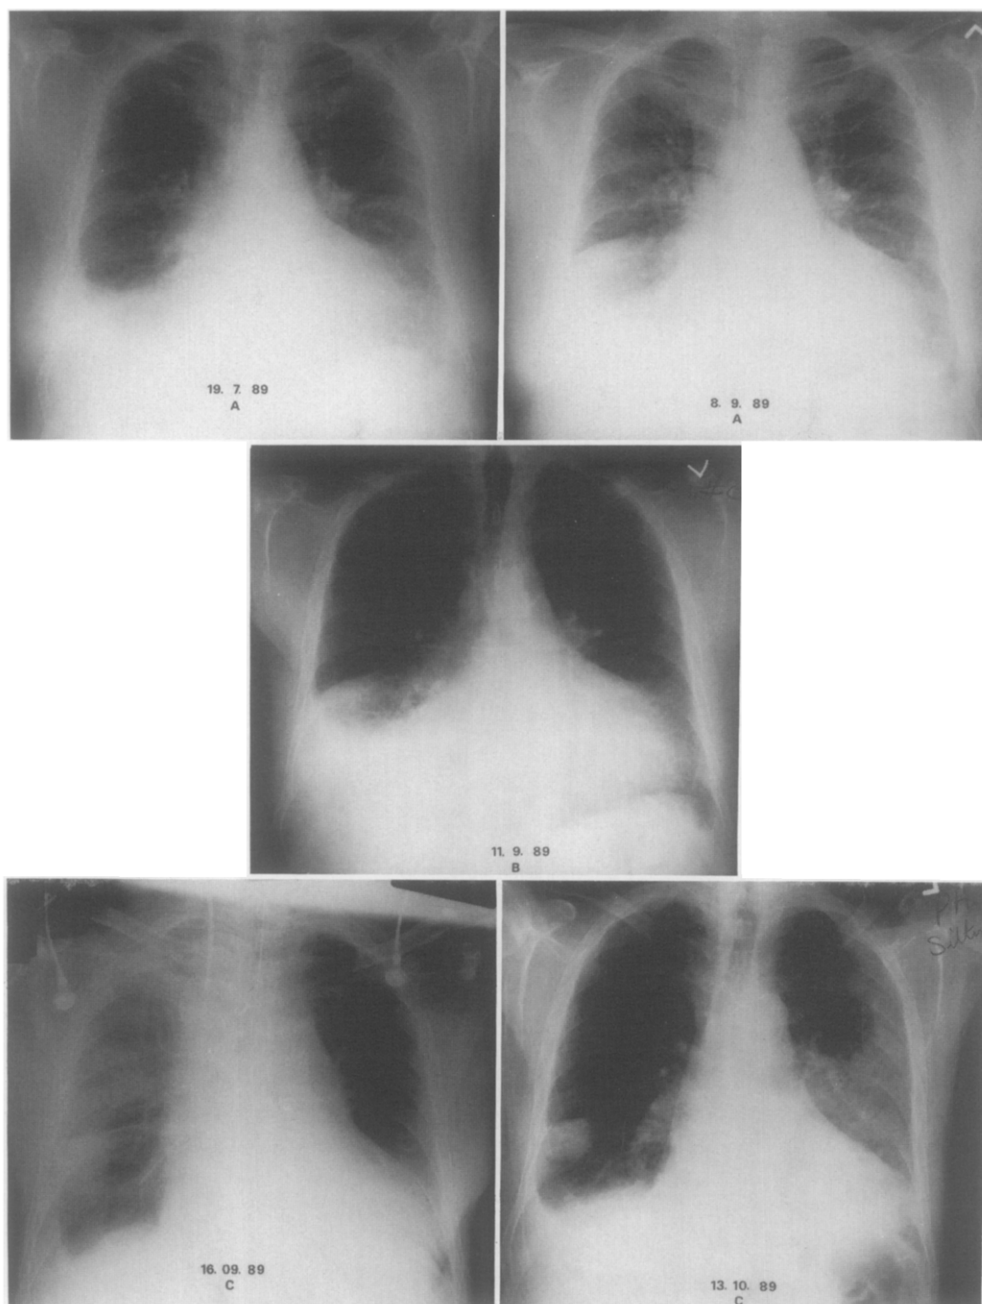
Chest radiographs obtained during the patient's stay in hospitals A, B and C on the dates indicated. The one designated 8.9.89A was obtained while the patient was attending as an outpatient. Radiographs marked 19.7.89A; 8.9.89A; 11.9.89B were obtained while the patient was afebrile and did not have any symptoms or signs of pneumonia. The radiograph marked 16.09.89C was obtained immediately after aortic valve replacement and coronary artery bypass grafting. The radiograph marked 13.10.89C shows a resolving left pulmonary opacity. Note the right pleural effusion on all radiographs and the non-resolving rounded opacity in the right lower lobe (interpreted as a pseudotumour).
